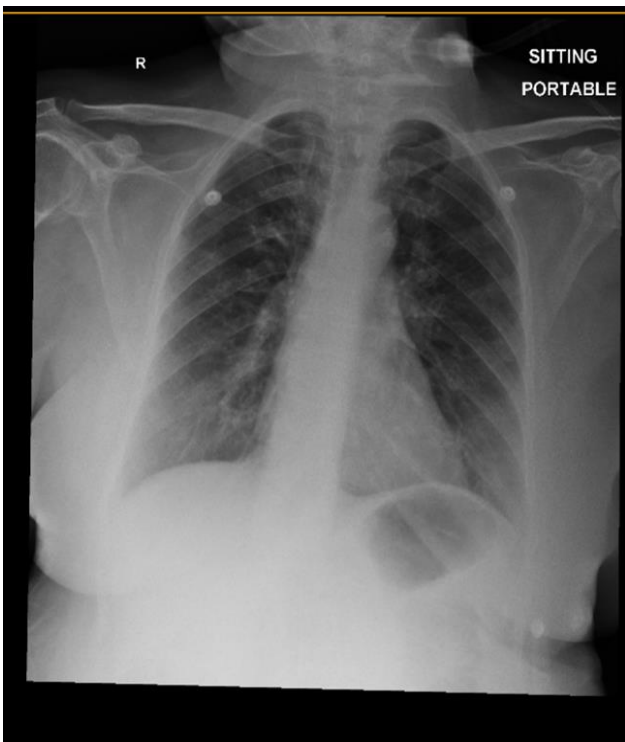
A chest radiograph showed increased bronchovascular markings and bilateral lower zone patchy opacities.
